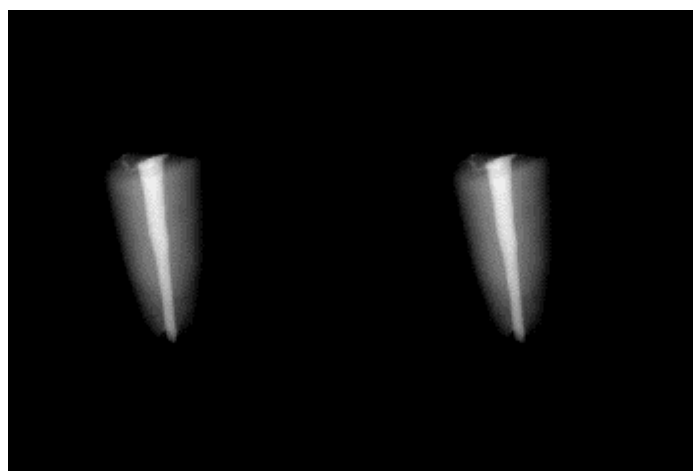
Radiographs showing obturation done.
